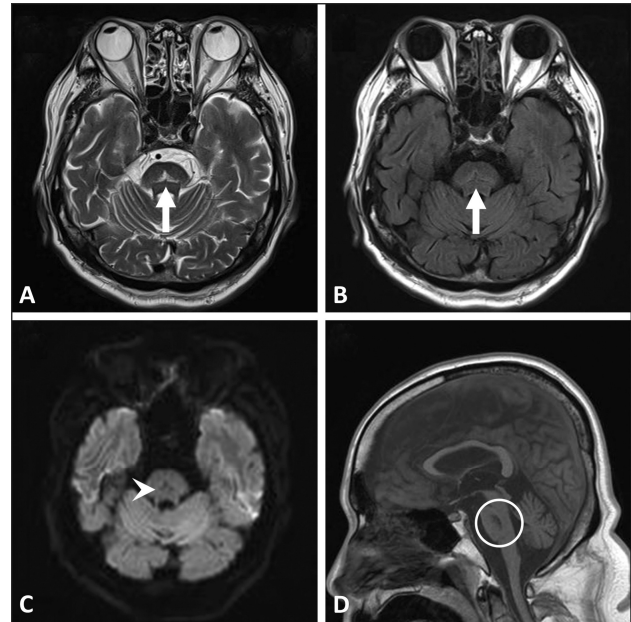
Brain MRI of the patient being treated for hyponatremia shows triangular high SI lesion that looks like a small lambda symbol (arrow) in the central pons on the T2-weighted image (A) and FLAIR image (B), and there is diffusion restriction (arrowhead) (C). T1-weighted sagittal image reveals low SI lesion (circle) in the pons (D). FLAIR: fluid attenuated inversion recovery, MRI: magnetic resonance image, SI: signal intensity.
